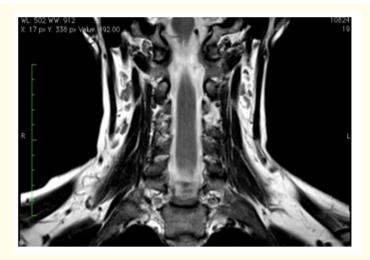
T2 coronal cervical spine MRI shows CSF leak in the left C3-C4 interspace.
